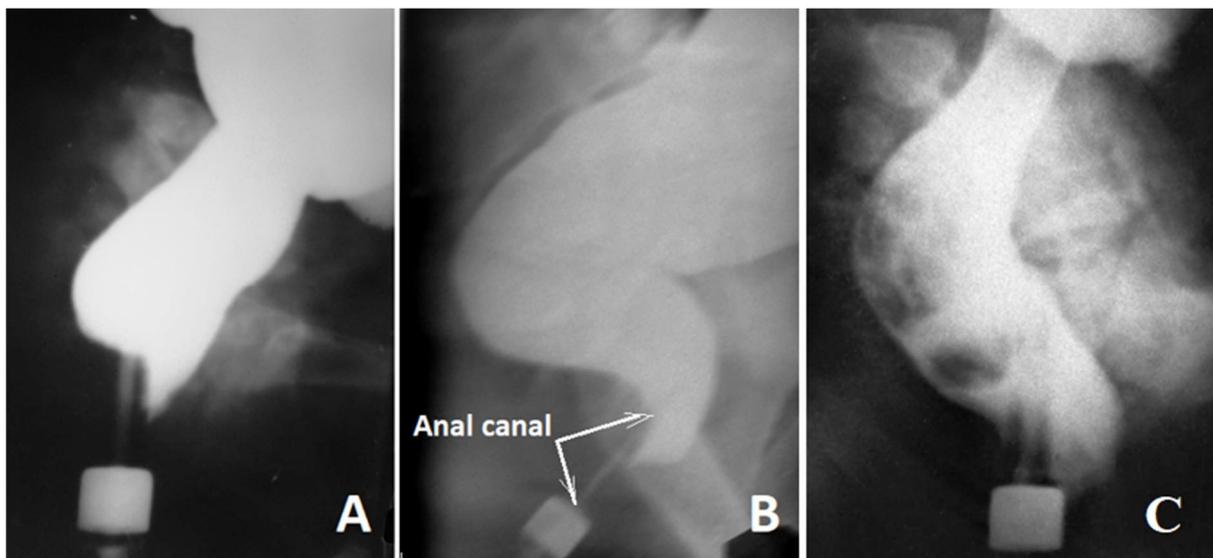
Lateral radiographs of the anorectal zone of patients without pathology of the digestive system. A). The penetration of barium into the upper part of the anal canal in front of the tip of the enema determines in infant as a result of IAS relaxation. The posterior wall of the anal canal is pressed against the tip by the contracted PRM. The axis of the anal canal almost coincides with the axis of the rectum. The anorectal angle is obtuse. B). In a patient of 14 years of age, the displacement of the rectum and the upper part of the anal canal is determined as a result of periodic contraction of the PRM for many years. The curved rectum forms a vertical and horizontal branch. The anorectal angle became acute. Relaxation of IAS is determined. C). During the barium enema, an attempt was made to defecate, which did not take place due to the contraction of the subcutaneous part of the external anal sphincter. The wide opening of the anal canal is determined as a result of the contraction of the levator plates as one of the components of the defecation reflex [14].
